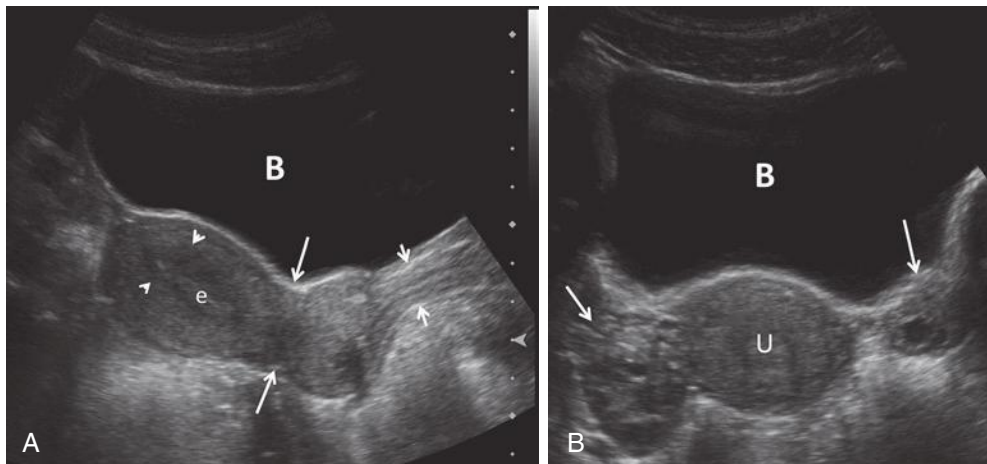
Transabdominal gray-scale ultrasound images of the normal uterus. A, Sagittal imaging plane. Note indentation below the lower uterine segment indicating the level of the internal os (*long arrows*), the striated appearance of the vagina (*short arrows*), the linear homogeneously echogenic endometrium (*e*), and the surrounding hypoechoic subendometrial halo (*arrowheads*). Note the acoustic window provided by the distended urinary bladder (*B*). B, Transverse imaging plane. Note the bladder (*B*), right and left ovaries (*arrows*), and uterus (*U*).
